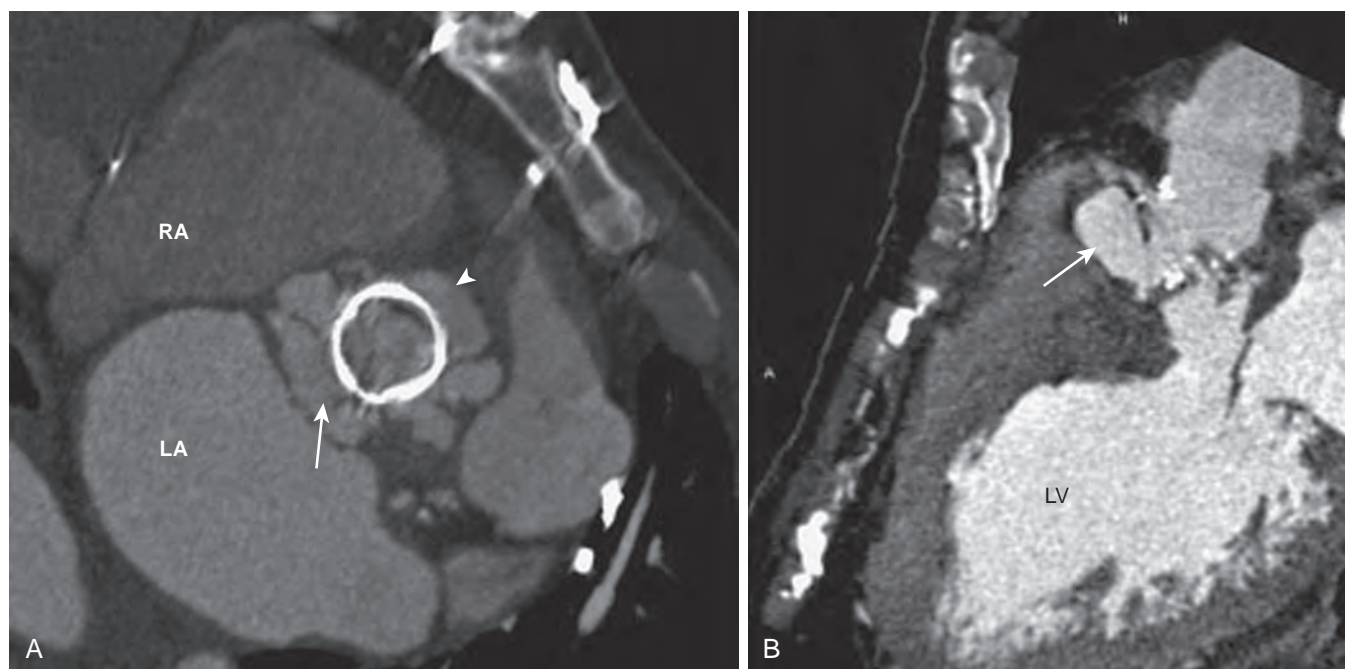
Computed tomography angiography of a bioprosthetic aortic valve (arrowhead) with a paravalvular abscess (arrow) in the short-axis view (A) and the three-chamber view (B). LA, Left atrium; LV, left ventricle; RA, right atrium.
